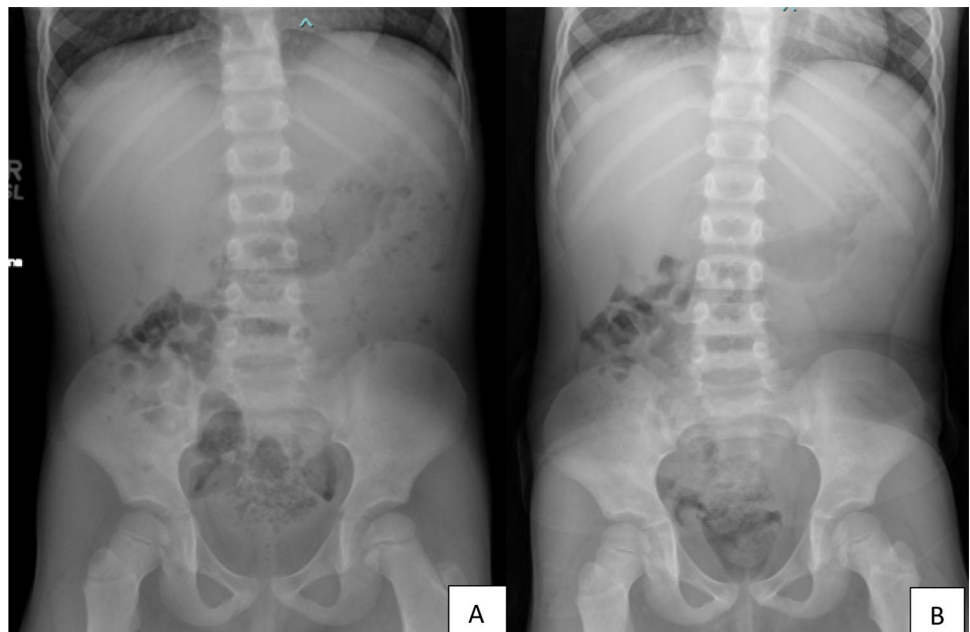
Patient with idiopathic constipation during bowel management with laxatives. A Abdominal radiograph with a large amount of stool in the rectum, transverse and right colon. B Clean abdominal radiograph after the laxative dose was increased
